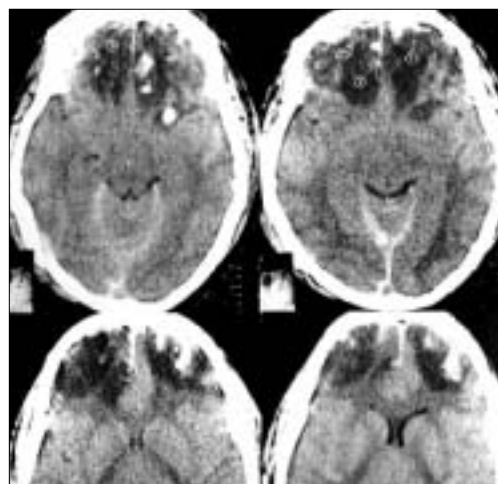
Second CT scan of case 3 showing significant increase in frontal contusions. This patient was treated conservatively, patient was conscious after second CT
